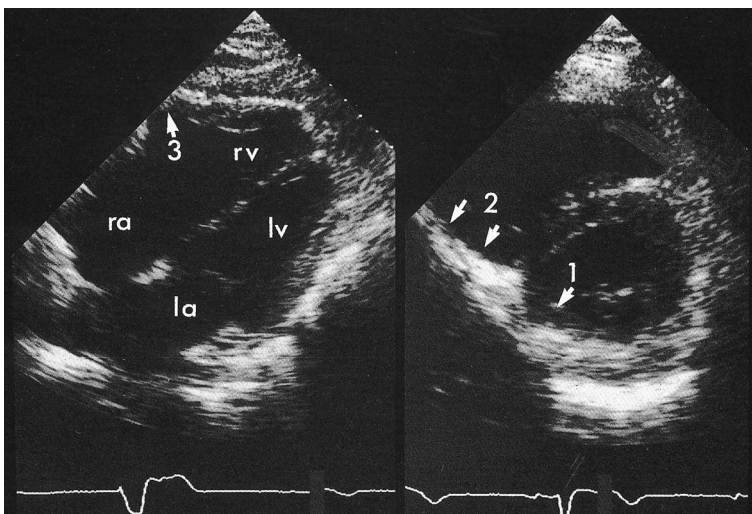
Two-dimensional echocardiogram demonstrating right ventricular dysfunction. There is an infarct of the inferior wall of the left ventricle (1) with thinning and akinesis of the adjacent part of the right ventricle (2) The base of the right ventricular free wall (3) is also affected.
